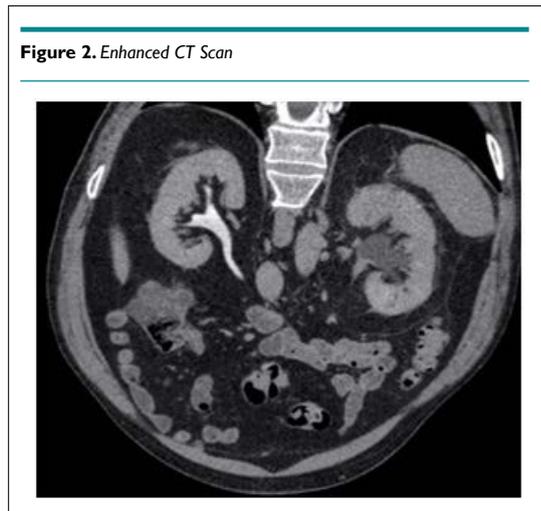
Enhanced CT Scan
